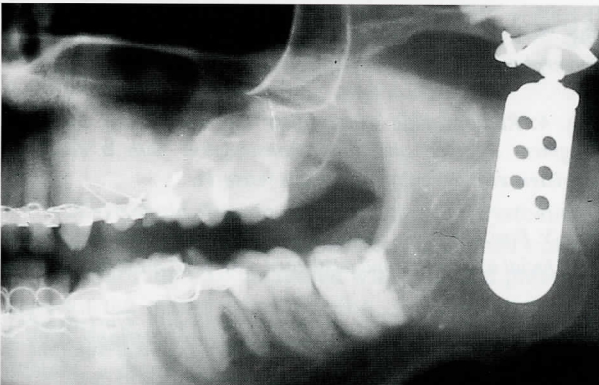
Radiographic image of the left TMJ reconstruction with a Christensen's articular prosthesis (case 2).
